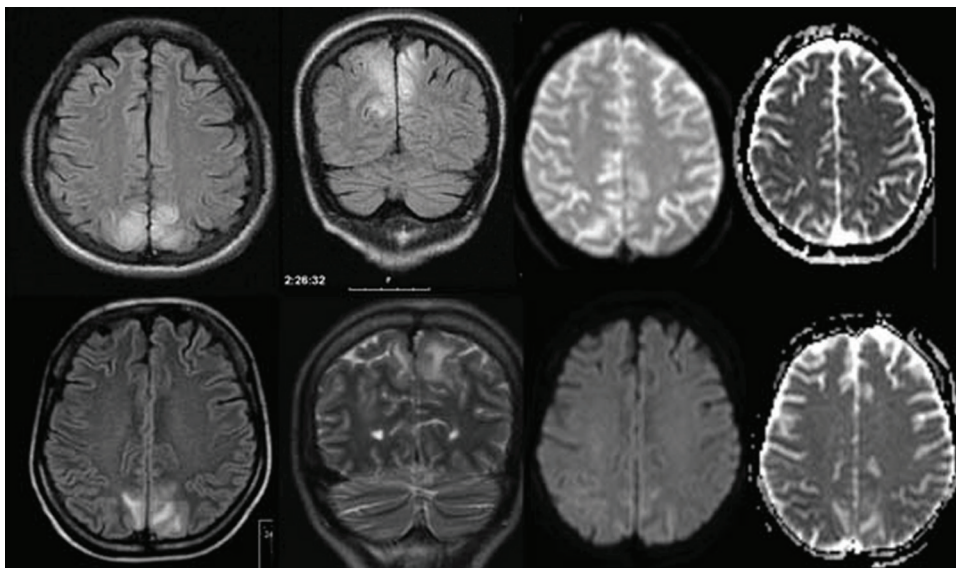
Brain MRI showing posterior hyperintense lesions on FLAIR/T2 sequences and no water restriction on DWI/ADC maps. Upper images form the first patient; bottom images from the second patient.
